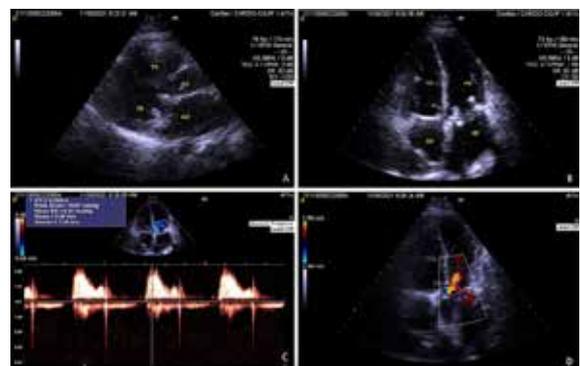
Postoperative transthoracic echocardiogram demonstrating good functionality of the new prosthesis
